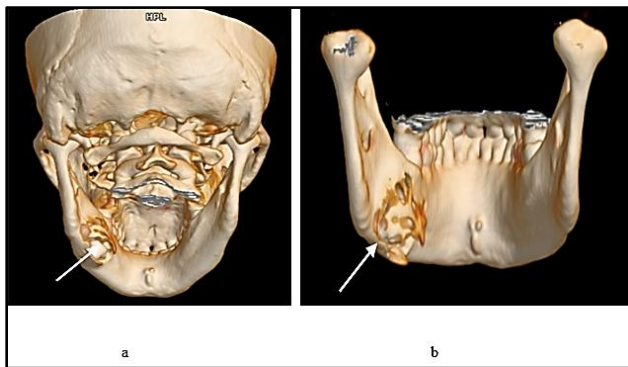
a & b: CT panoramic reconstruction of the mandible showing bony lytic lesion involving the left side body of the mandible with an unerupted left third molar tooth (arrow).
